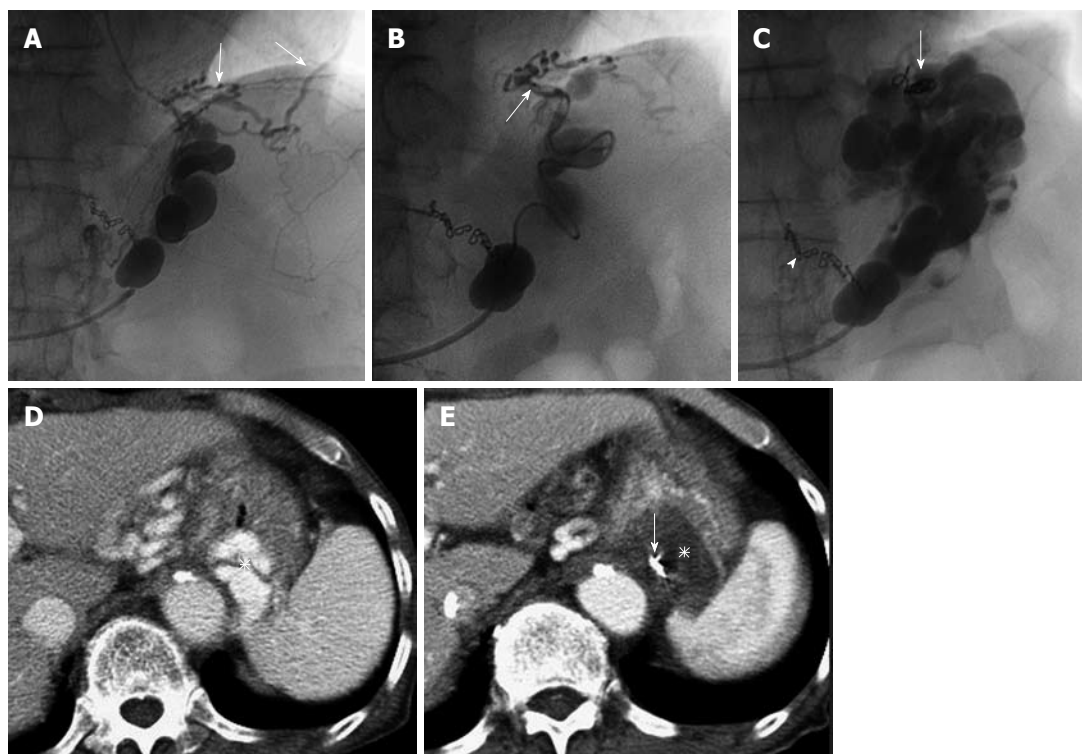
Microcoil embolization of collateral veins. A: Pericardiophrenic veins (arrows) develop as collateral draining veins; B: A microcatheter (arrow) is navigated into the pericardiophrenic vein and microcoil embolization is performed; C: The sclerosant is selectively injected through the microcatheter which is withdrawn a little, and the gastric varices are opacified sufficiently. Microcoils (arrow) from embolization and surgical clips from previous operation of gastric cancer. (arrowhead) are seen; D: Contrast-enhanced computed tomography (CE-CT) before balloon-occluded retrograde transvenous obliteration (BRTO) shows gastric varices (asterisk); E: CE-CT next day after BRTO shows complete thrombosis of the varices (asterisk) and microcoils close to the varices (arrow).
